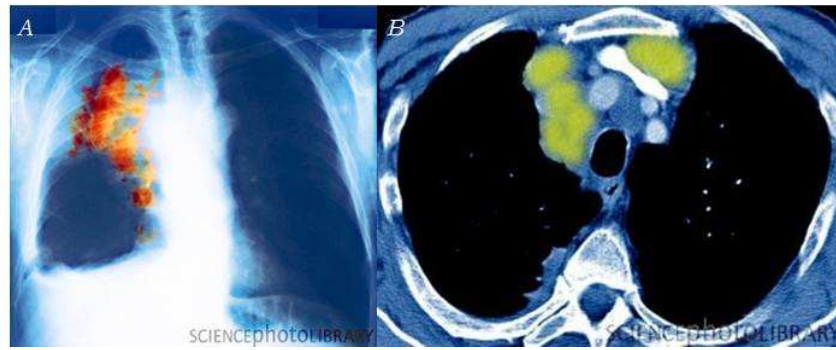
SCLC Imaging. A Coloured X-ray of the chest of a patient with small cell lung cancer (orange tumours, upper left, right lung). B Coloured CT scan in axial section through the chest showing cancerous lymph nodes (adenomegaly, yellow) as the primary site of SCLC. (Pictures adapted from www.sciencephoto.com)
